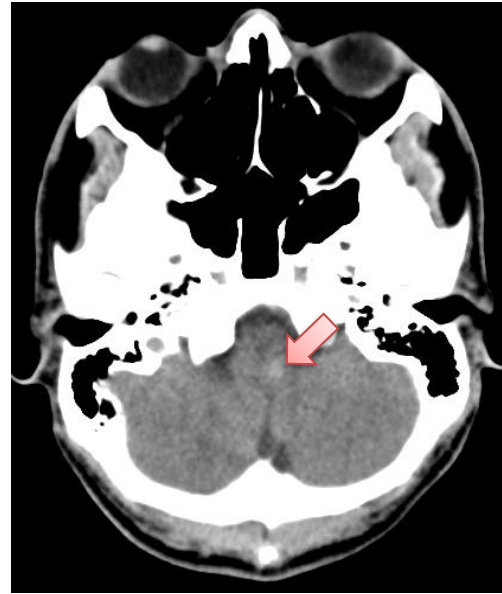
CT scan of the head after 7 days of treatment
